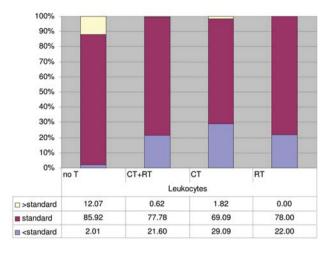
Percentage of breast cancer patients with leukocyte counts within/below/above the normal range as shown in Table I. No T: no adjuvant therapy; CT: adjuvant chemotherapy; RT: adjuvant radiotherapy.
